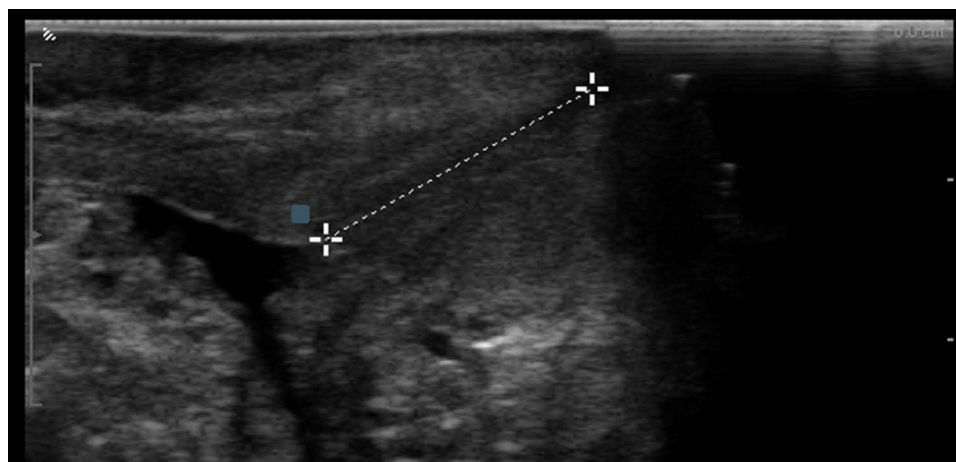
Preoperative transvaginal midsagittal sonographic view of the urethra, using an endocavitary linear probe. Ultrasound evaluation showed a shortened urethra – measuring 18mm – due to an undiagnosed obstetric urethral tear.
